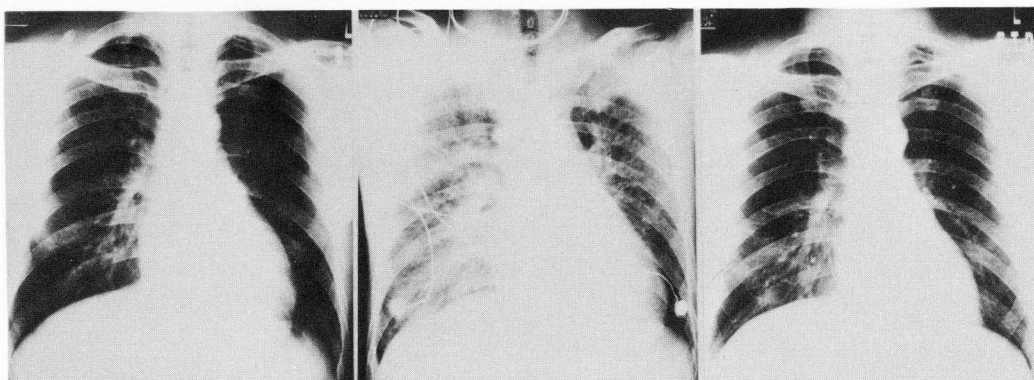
Chest X-ray on admission of December 12 (left), December 15 (middle) 1978 and March 1 1979 (right). The middle figure shows increased CTR and pulmonary edema.
